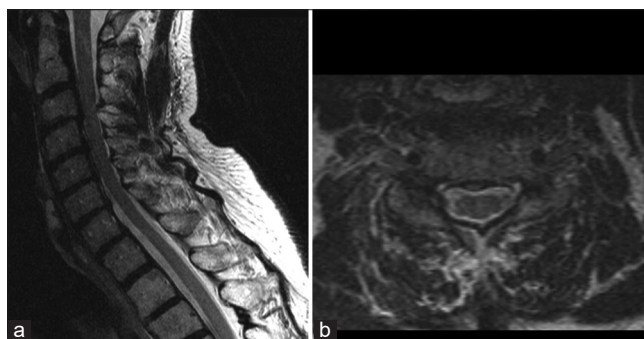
Cervical spine MRI obtained at 1 month follow-up with (a) T2-weighted sagittal view and (b) T2-weighted axial views demonstrating complete resolution of hematoma with resolution of previously demonstrated cord compression.
